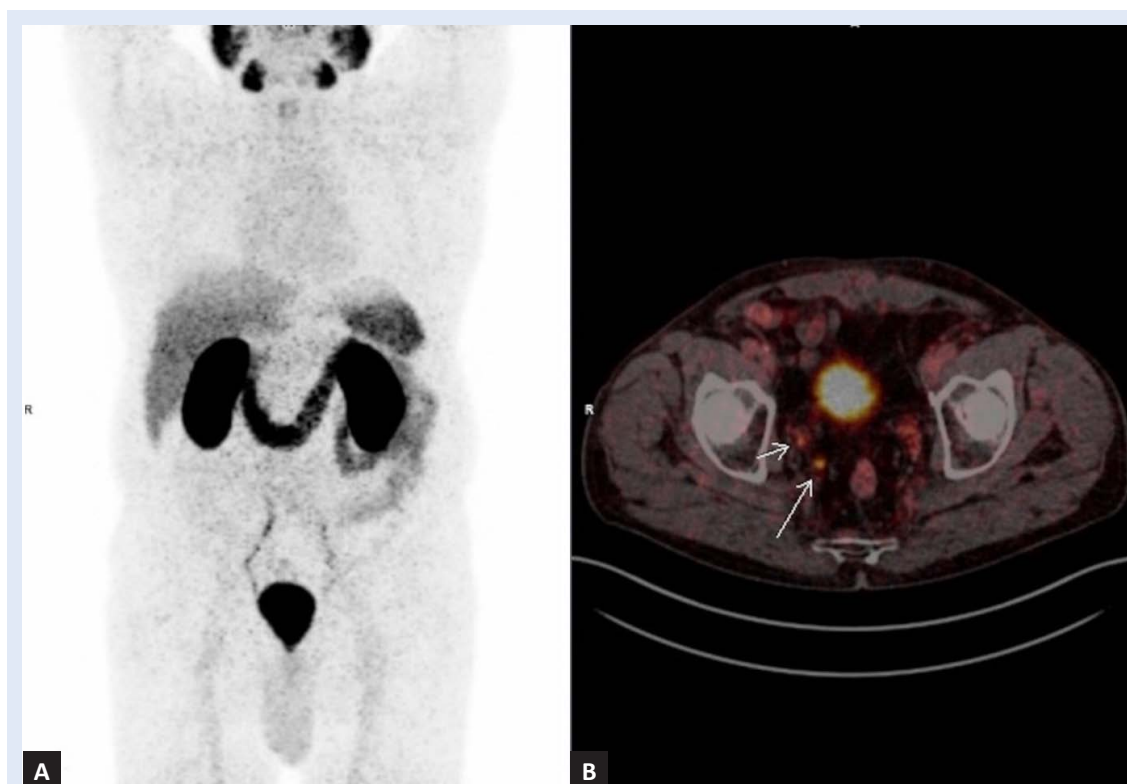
Gallium-68 PSMA-11 PET/CT imaging of 67 years old patient referred after radical prostatectomy due to biochemical recurrence (PSA 0,21 ng/ml), demonstrating lymph node metastasis. A: Whole body MIP (Maximum intensity projection) PET image, B: Axial PET/CT image showing PSMA uptake in the right internal iliac lymph node metastasis (long arrow) and physiological activity in right ureter (short arrow). From the archives of the Clinical Department of Nuclear Medicine and Radiation Protection, University Hospital Centre Zagreb, Zagreb, Croatia.
